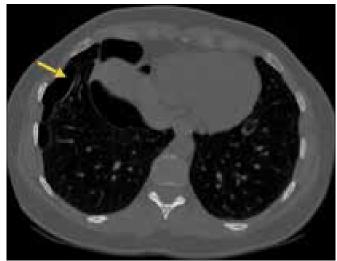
(C) CT showing subpleural cysts (yellow arrow).
